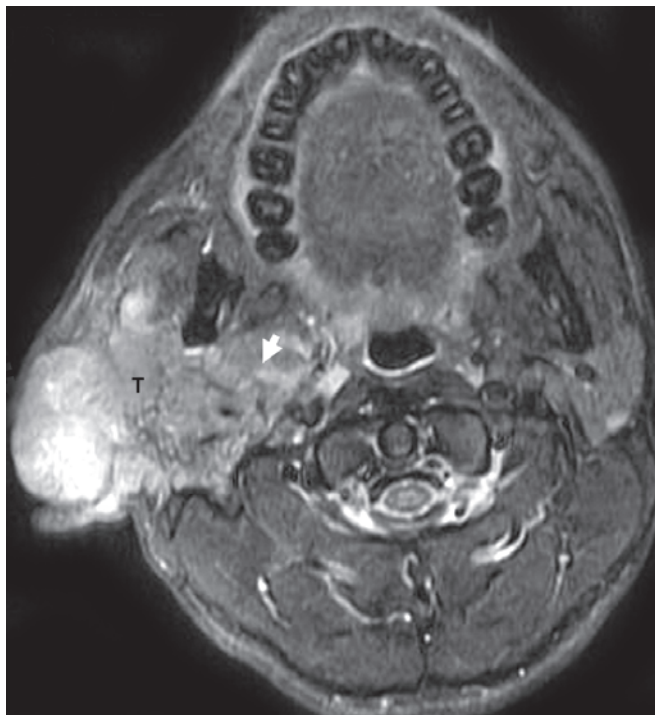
Axial T1 weighted, fat suppressed, contrast enhanced MR image shows heterogeneously enhancing solid mass lesion (T) involving both superficial and deep lobes (small white arrow) of right parotid gland. The portion of the lesion in the lateral aspect is infiltrating the skin (dashed white arrow) and shows more enhancement. This was a carcinoma ex pleomorphic adenoma
